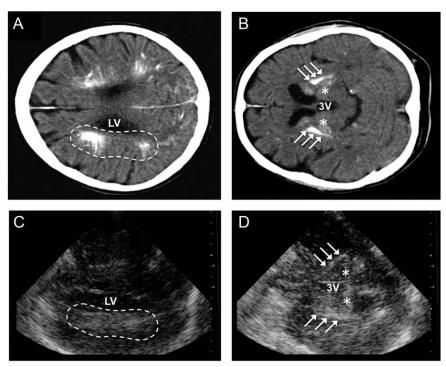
The CT brain scan revealed profound periventricular calcium deposits (A, dotted line; LV, lateral ventricle) and intense calcifications of both striata (B, \rightarrow) as well as (lower) parts of the thalamus (B, *) adjacent to the third ventricle (3V), whereas brainstem structures including SN showed normal findings in CT and MRI scans (not shown). The TCS images of the cella media level (C) and diencephalic level (D) showed marked hyperechogenic areas corresponding to the hyperintense areas as shown in (A) and (B).
